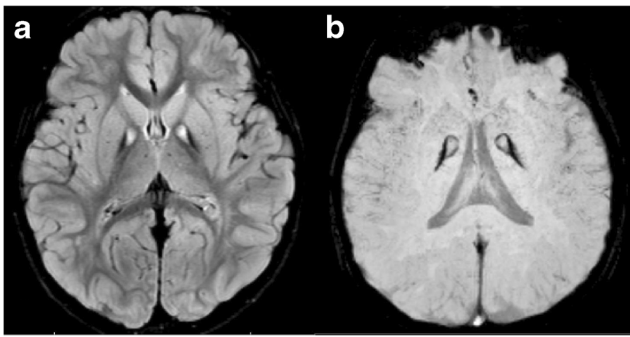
A 4-year-old patient with pantothenate kinase-associated neurodegeneration (PKAN) showing the typical eye-of-the-tiger appearance of the globus pallidus on FLAIR (a) and SWI (b)
